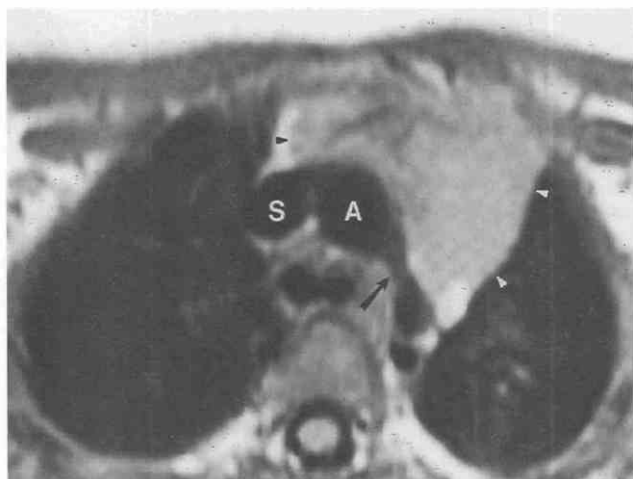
Normal thymus in 9-month-old child with coarctation of the aorta. Axial T1-weighted MR image shows thymus gland (arrowheads) in the mediastinum anterior to the aorta with homogeneous, intermediate signal intensity less than that of fat. The arrow indicates aortic coarctation. A, aorta; S, superior vena cava. (Case courtesy of Donald Frush, M.D., Duke University Medical Center, Durham, NC.)
